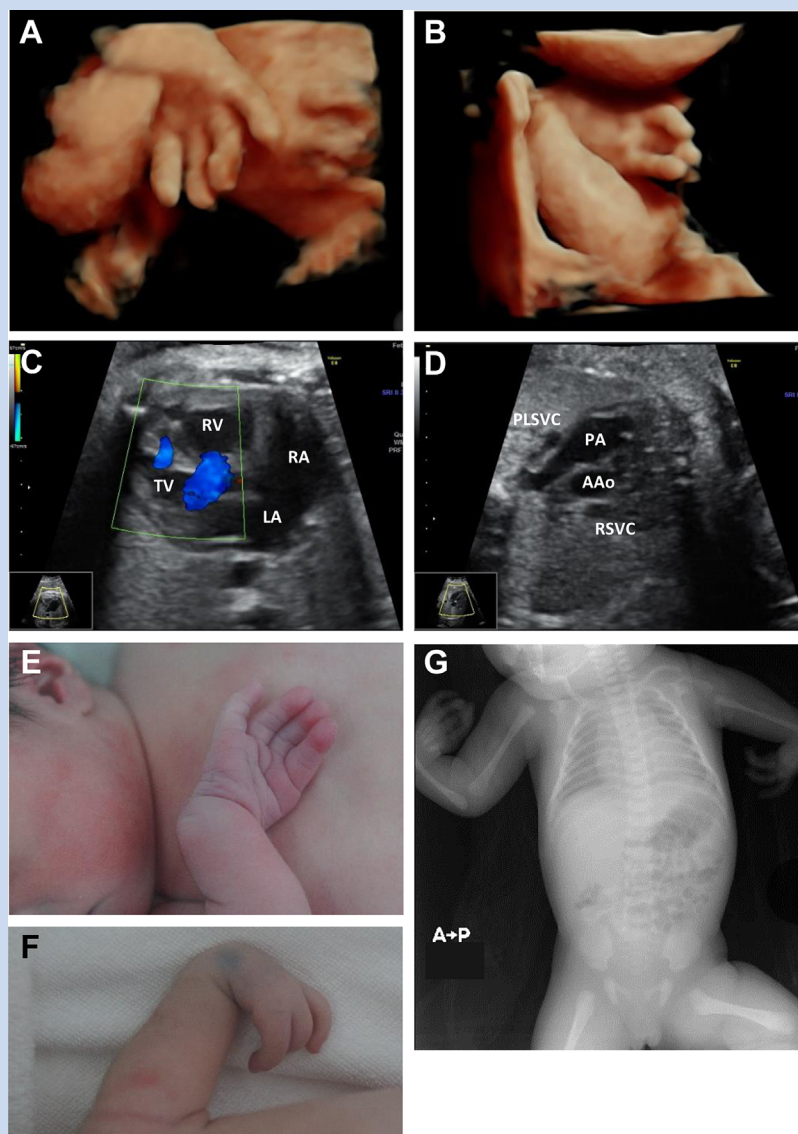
Clinical photographs of an HOS patient. (A and B) 3-D ultrasonographic images of the fetal upper limbs. The right hand (A) showed absence of thumb, with radial deviation of the wrist, whereas the left hand (B) showed stiff fingers, and absence of thumb and index finger with radial deviation of the wrist. (C and D) Echocardiographic images of the fetus. A four-chamber view (C) showed large perimembranous and muscular VSD, and a three-vessel view (D) showed supernumerary fourth vessels [persistent left superior vena cava, PLSVC] to the left of the pulmonary artery [PA], LV, left ventricle; LA, left atrium; RV, right ventricle; RA, right atrium; AA, ascending aorta; RSVC, right superior vena cava. (E and F) Postnatal appearance of bilateral upper limbs. The right upper limb (E) had a radially bowed forearm, radial deviation of the wrist associated with flexion deformity at the elbow and wrist joint and absence of thumb, whereas the left upper limb (F) had a shortened middle segment, stiff fingers and absence of thumb, and index finger. (G) X-rays of the infant showing the absence of the radius and thumb in the right upper limb and absence of radius, thumb and index finger with hypoplastic humerus in the left upper limb. [Color figure can be seen in the online version of this article, available at <http://wileyonlinelibrary.com/journal/ajmga>].
